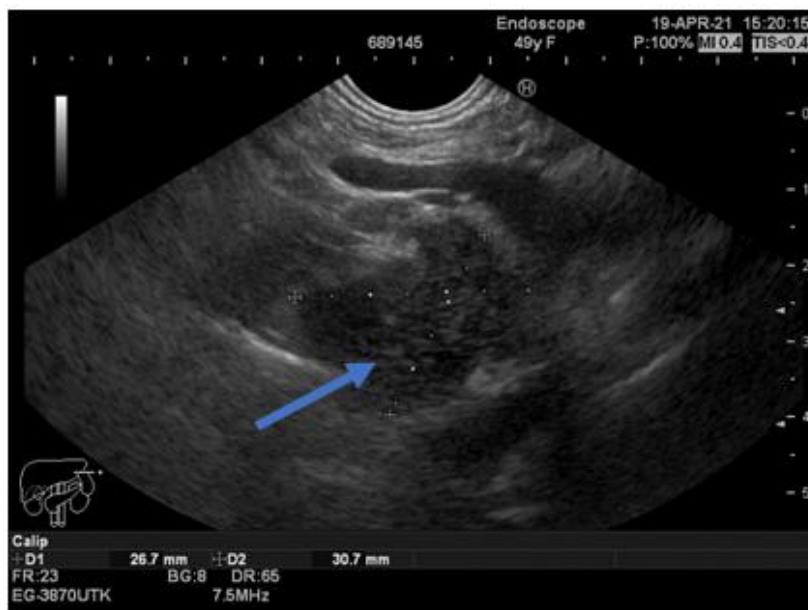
Ultrasound endoscopic appearance of the pancreatic masse (blue arrow)
